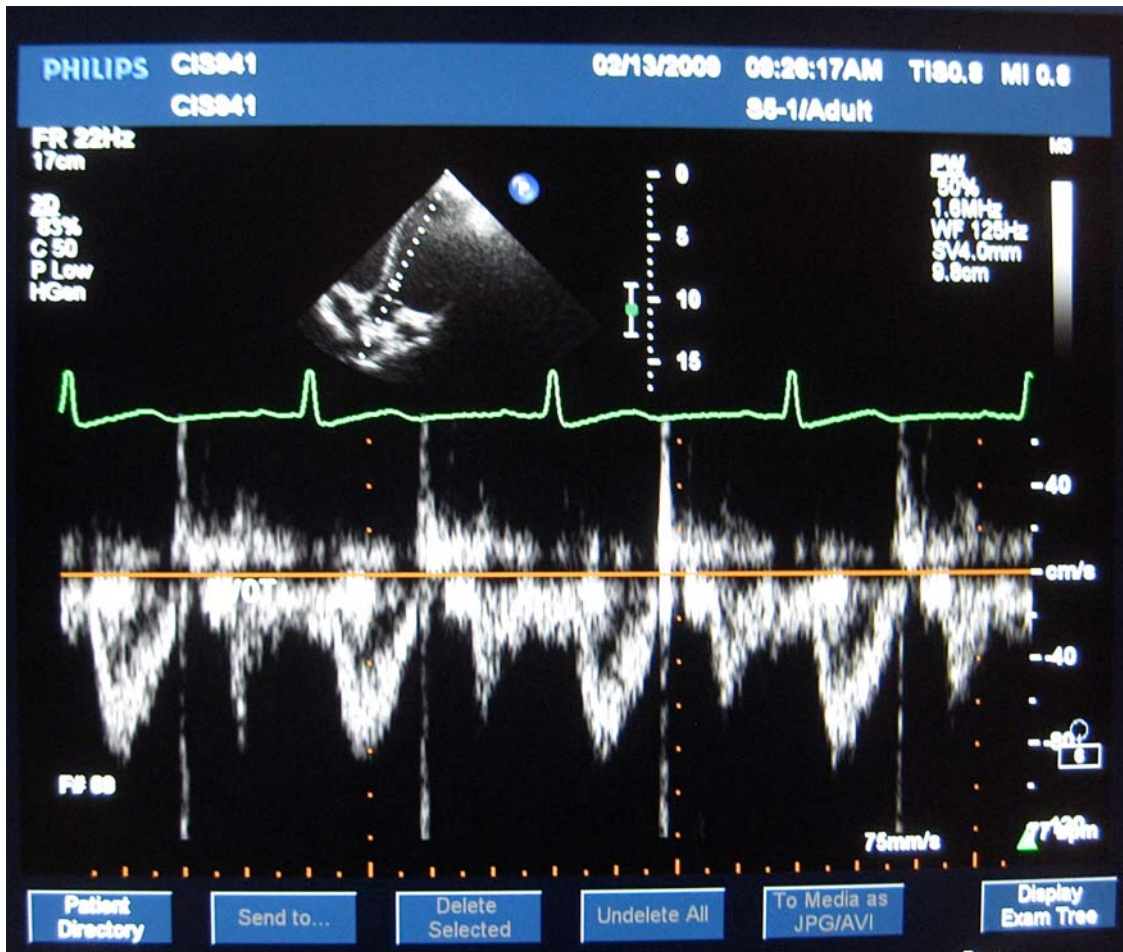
LVOT Doppler velocity for VTI calculation
